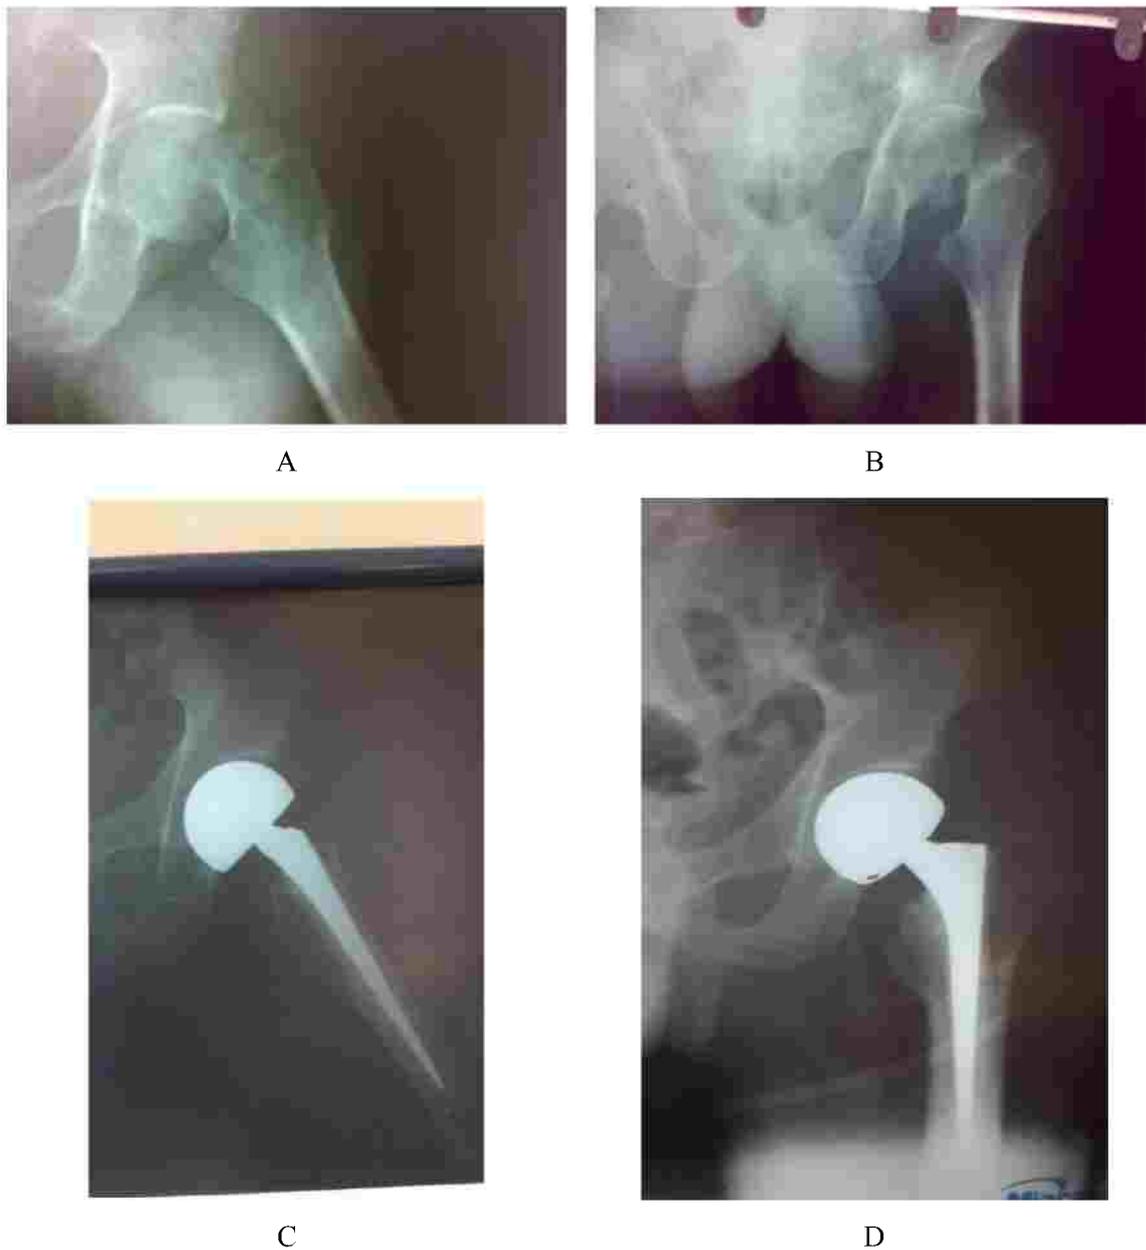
(A, B) Pre operative X-rays show Garden 4 fracture neck of femur (C, D) Postoperative X-rays with bipolar hemiarthroplasty properly positioned stem that is central in AP and lateral view with well contained head
